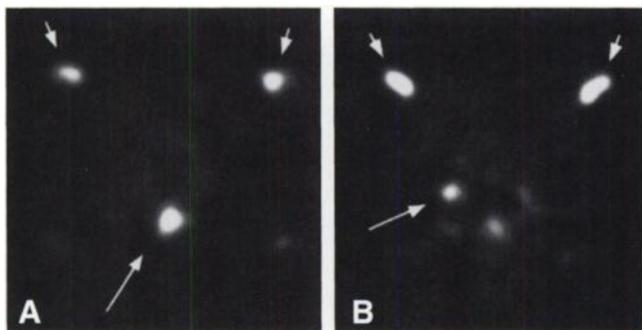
Transaxial PET images of the pelvis, obtained after injection of ^{64}Cu -MAB 1A3 (7 mg, 10 mCi), in a man with biopsy-proven recurrent rectal carcinoma. CT (not shown) was equivocal for tumor, but MAB-PET clearly showed a 2-cm recurrent tumor (long arrow in panel A) as well as a nodal metastasis (long arrow in panel B) superior and lateral to the tumor. Blood-pool activity is seen anteriorly in both external iliac vessels (short arrows).
